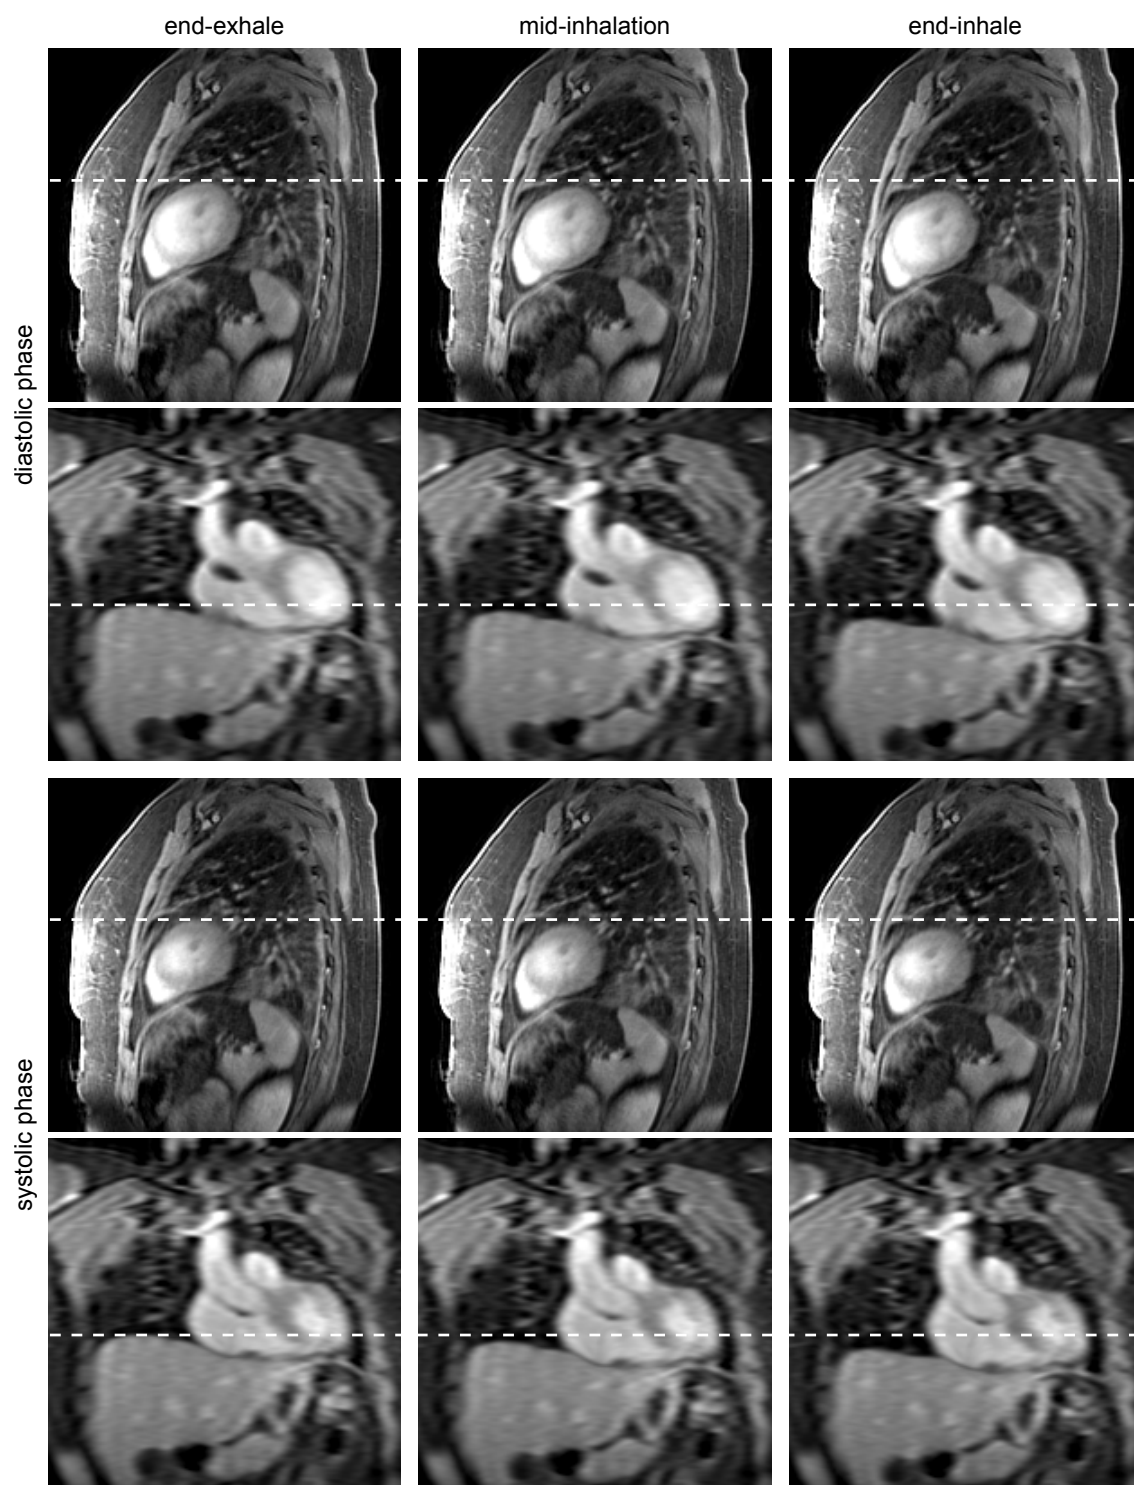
5D MRI study: MR image reconstruction of different combinations of respiratory and cardiac motion phases from a 58-year-old female patient (p06). Images were acquired in sagittal orientation and the slice direction was upsampled to isotropic resolution for visualization.
